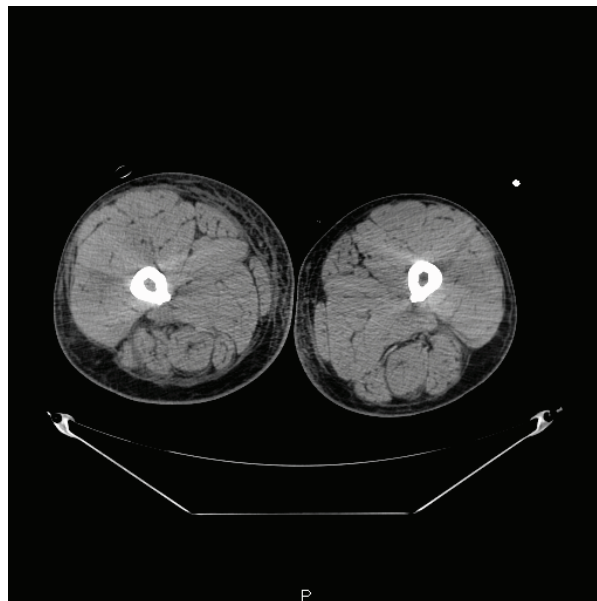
CT scan without contrast. Diffuse soft tissue swelling seen bilaterally without gas or abscess.
